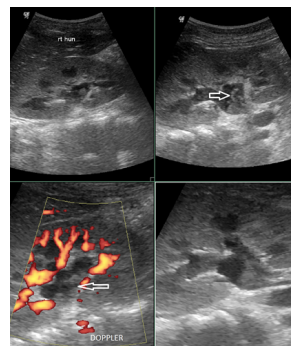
Ultrasonogram image showing right proximal hydronephrosis and an heteroechoic avascular focus in the renal pelvis (Arrows).
